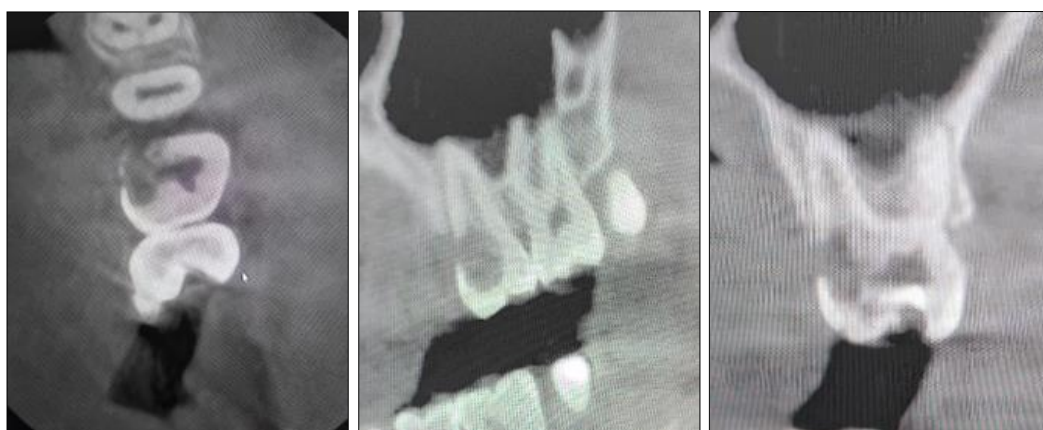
Cone beam computed tomography (CBCT) of the left maxillary first molar- (a)axial, (b)coronal, (c)sagittal views confirmed the presence of external cervical resorption (ECR) showing lesion is well-defined, located near the coronal pulp, with a possible connection to the pulp chamber and also little extension into the root dentin.
